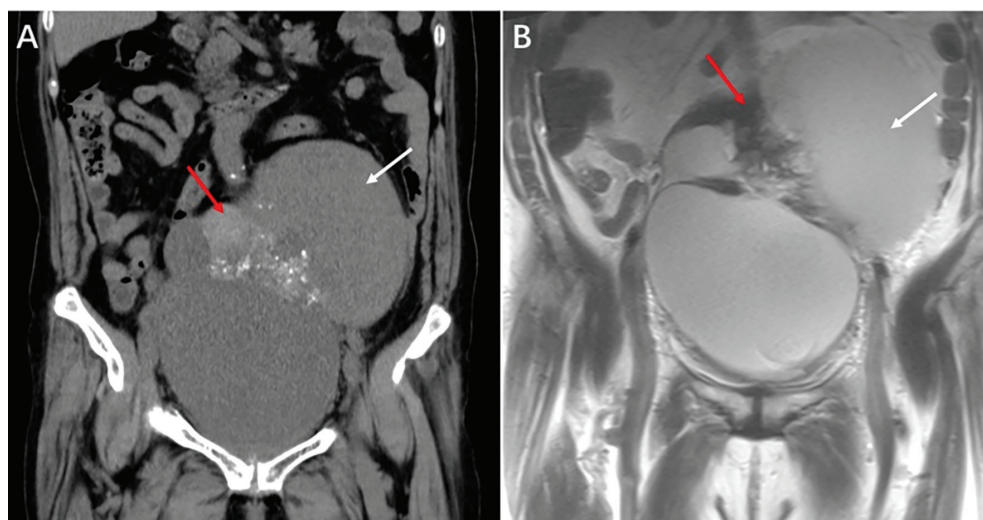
Coronal computed tomography and coronal magnetic resonance imaging demonstrate a large cystic-solid pelvic mass
